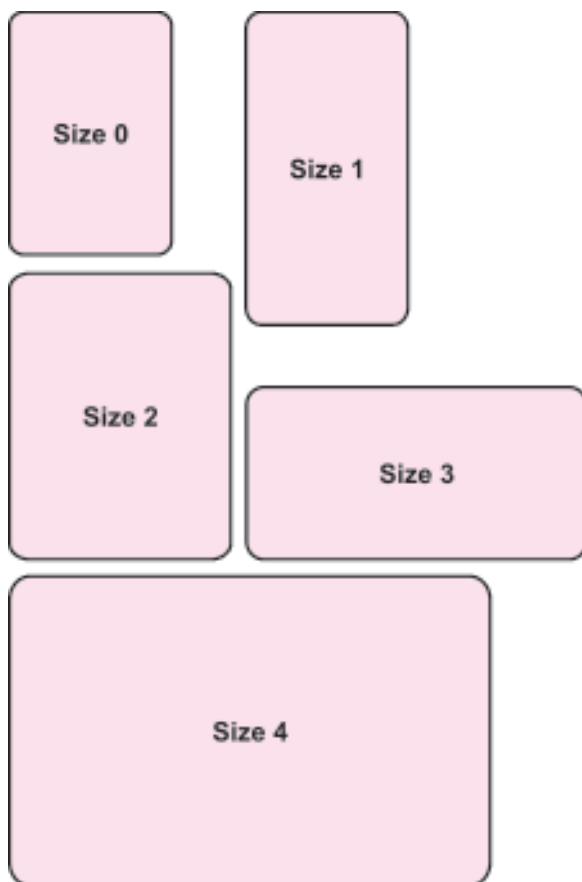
Intraoral film sizes: size 0 for child, size 1 for narrow anterior, size 2 for adult, size 3 for bitewing and size 4 for occlusal
